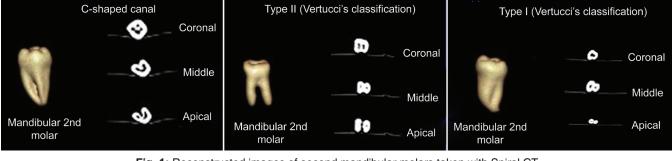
Reconstructed images of second mandibular molars taken with Spiral CT
